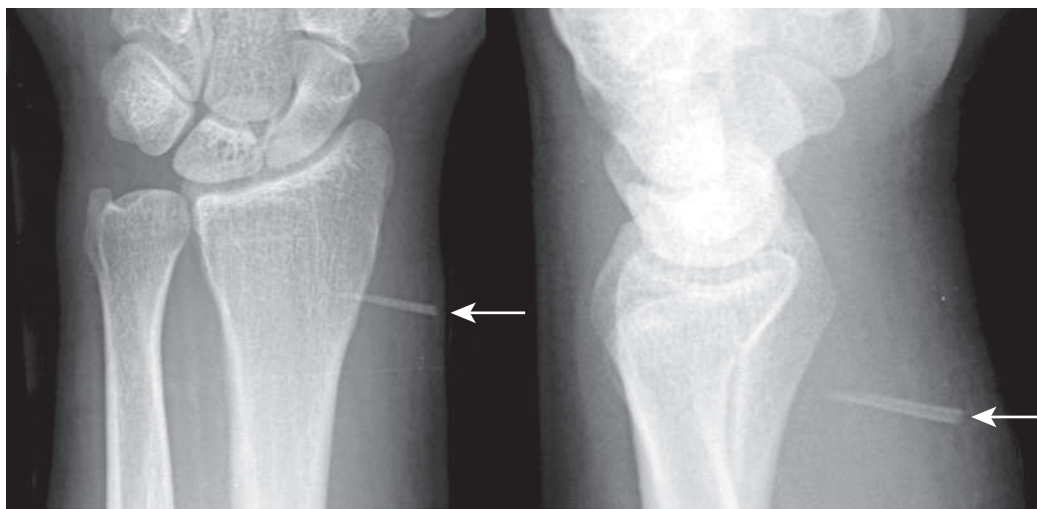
Plain films with a catfish fin in the volar wrist. (Courtesy Ekkehard Bonatz.)
